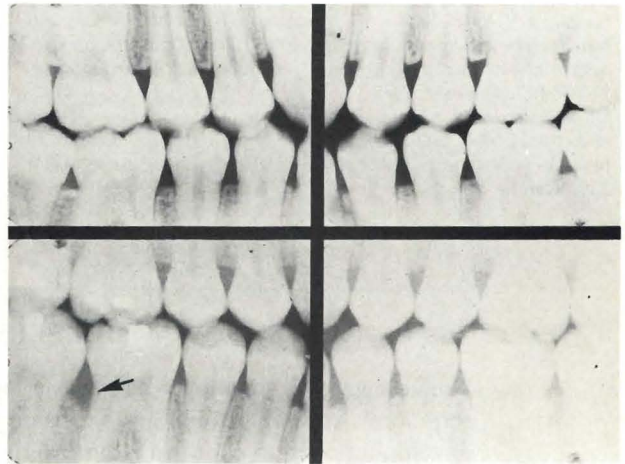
Bitewing radiographs of brother M.T. Top pair: 5-5-81; Bottom pair: 3-21-84. Note the bone loss in conjunction with the lower right first molar (arrow).
